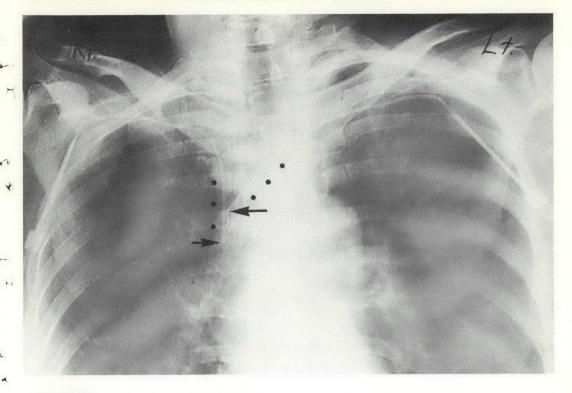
(a) Anteroposterior and (b) lateral radiographs showing the relative catheter positions.
